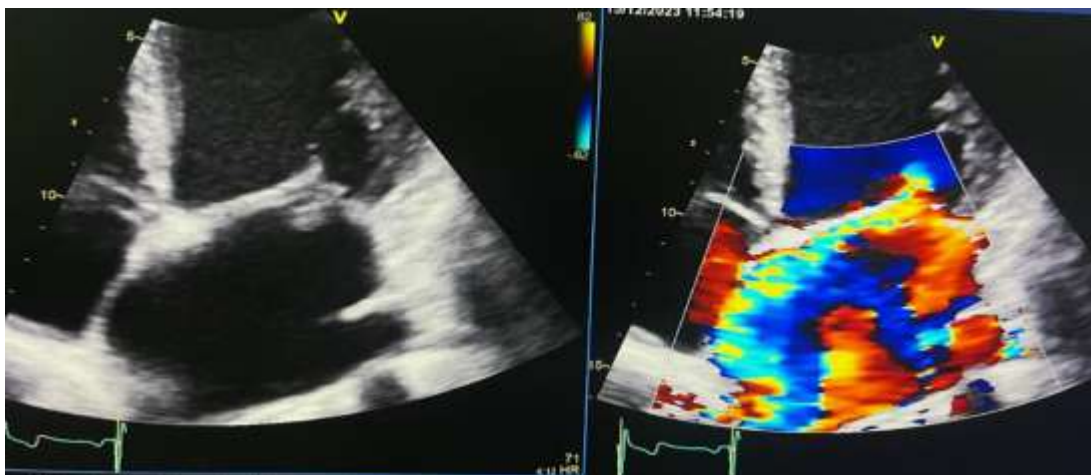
Apical 4 chamber view showing the P1 prolapse with a severe eccentric mitral regurgitation.
